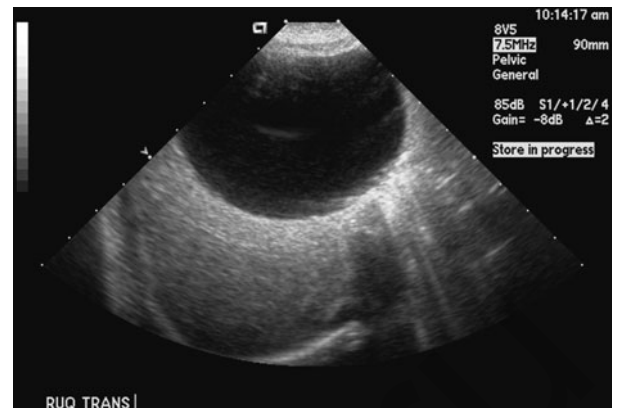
Transabdominal ultrasound of a simple ovarian cyst, 5.5 × 6 cm. Note the lack of internal echoes and no perceptible cyst wall.
